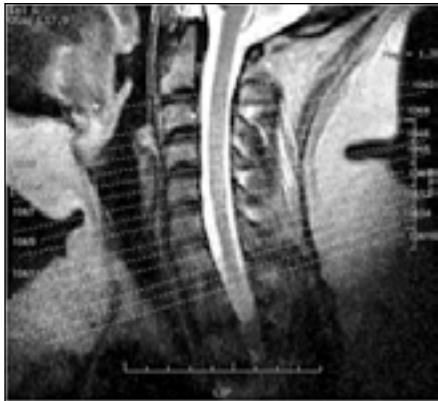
Typical Cervical Spine Axial MRI
